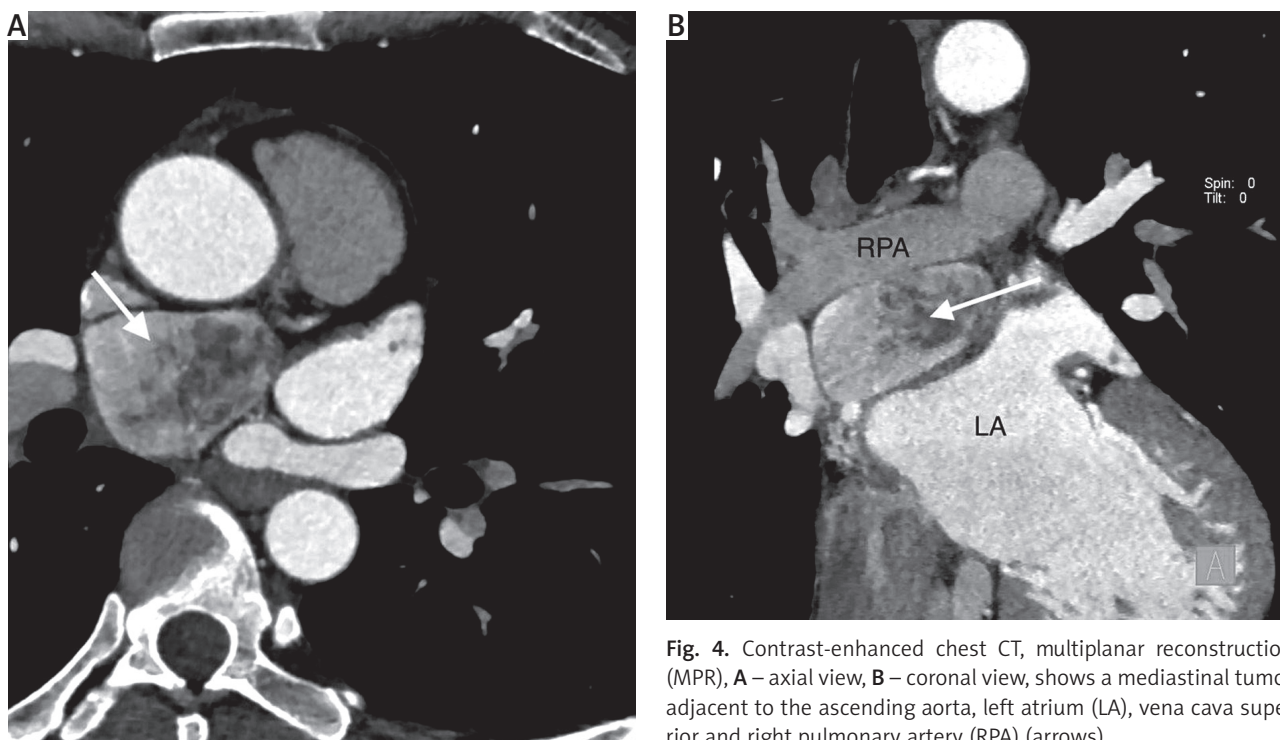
Contrast-enhanced chest CT, multiplanar reconstruction (MPR), A – axial view, B – coronal view, shows a mediastinal tumor adjacent to the ascending aorta, left atrium (LA), vena cava superior and right pulmonary artery (RPA) (arrows)
